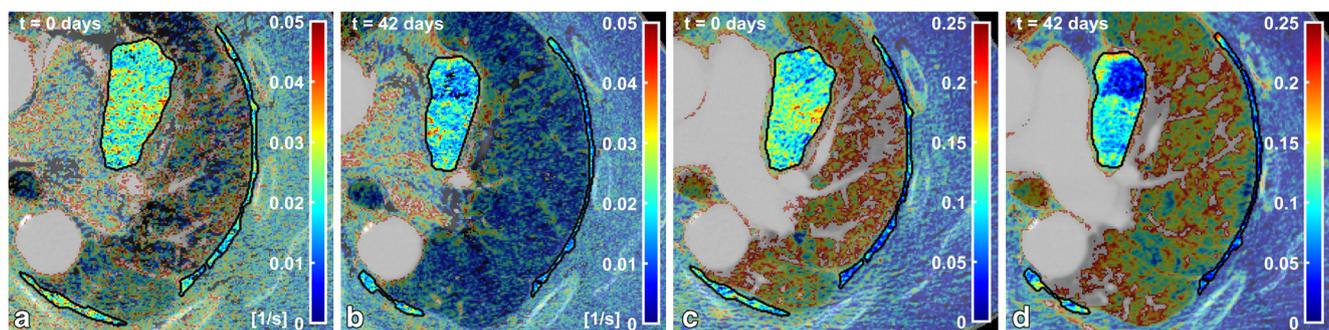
Example DCE-CT parameter maps of a patient on vorinostat treatment in this study: BF parameter map, a scan 1, b scan 2; BV parameter map, c scan 1, d scan 2. MPM tumour regions shown with black solid lines. The parameter map outside tumour regions is partially transparent and overlaid on the corresponding greyscale CT section. This
